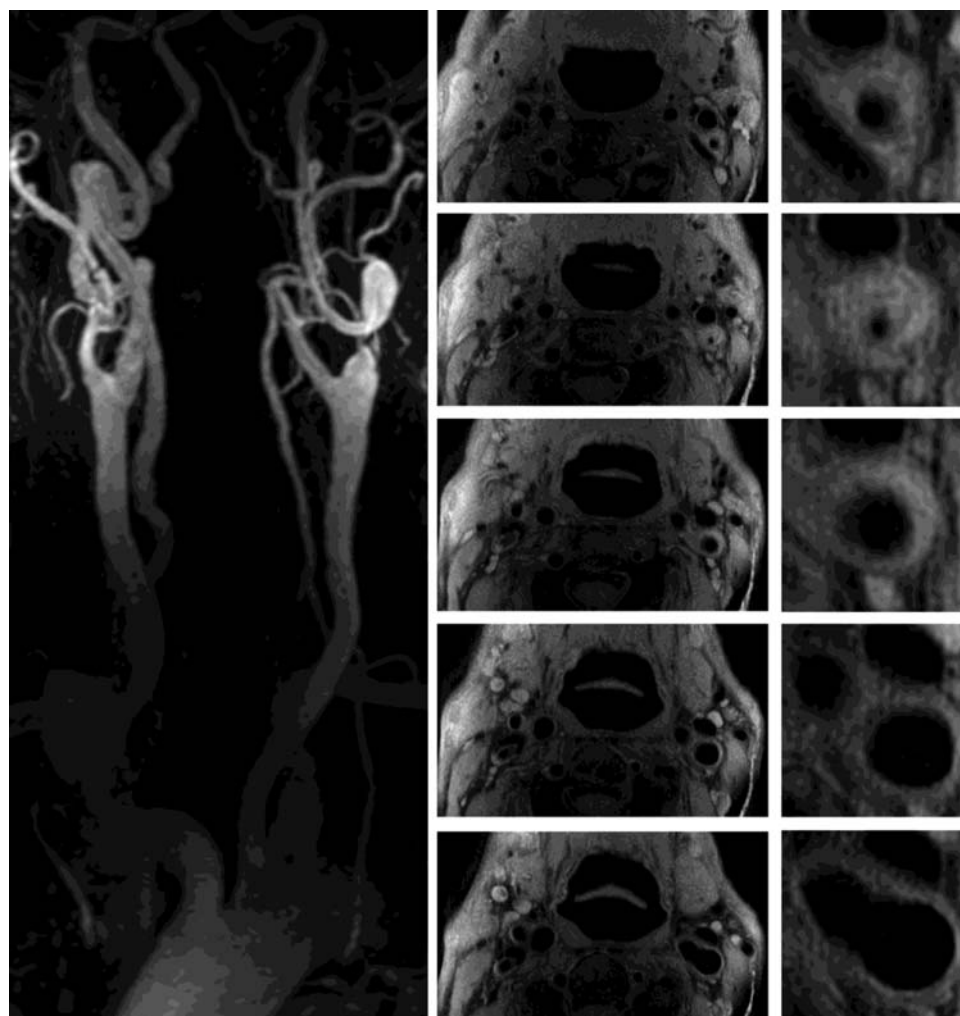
Magnetic resonance imaging of the carotid artery in a patient with arterial hypertension. The angiography with intravenous injection of gadolinium demonstrates a subtotal stenosis of the left carotid artery followed by a 360° loop due to the elongation of the artery. High-resolution magnetic resonance imaging allows visualization of the extension of the atherosclerotic plaque and anatomical distribution in relation to the surrounding structures.⁹
